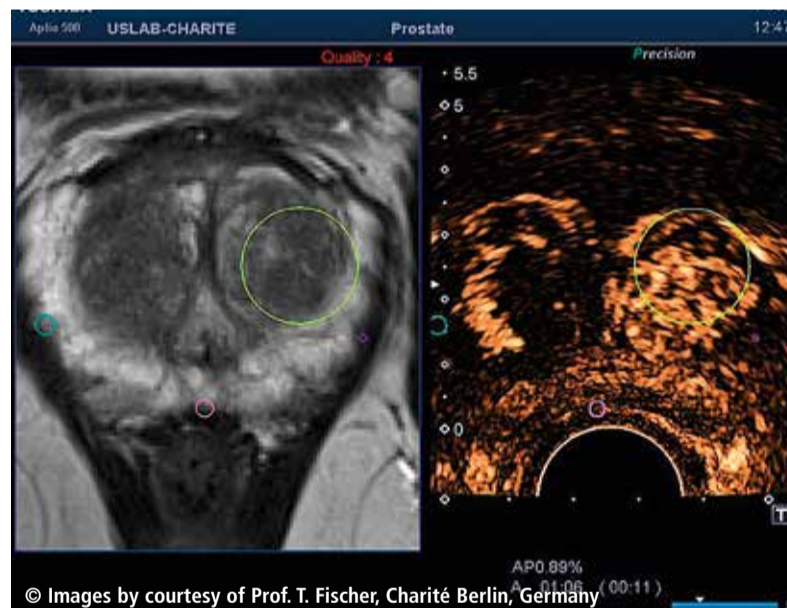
Image fusion of MRI and CEUS
